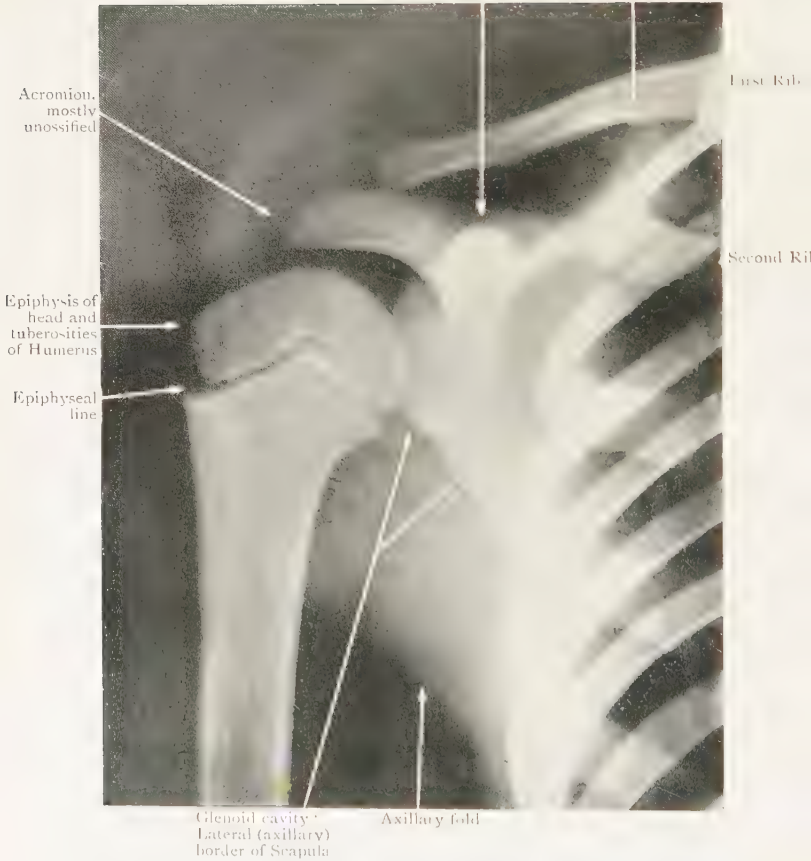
Radiograph of Shoulder Region of boy aged 11.
